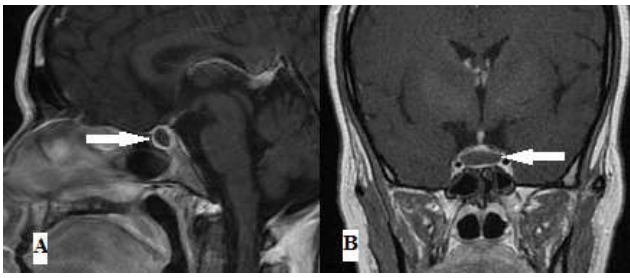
T1-weighted coronal (A) and sagittal (B) postcontrast images of cranial MRI performed on postpartum day one, revealing an enlarged pituitary with peripheral enhancement and no central enhancement (arrows)
